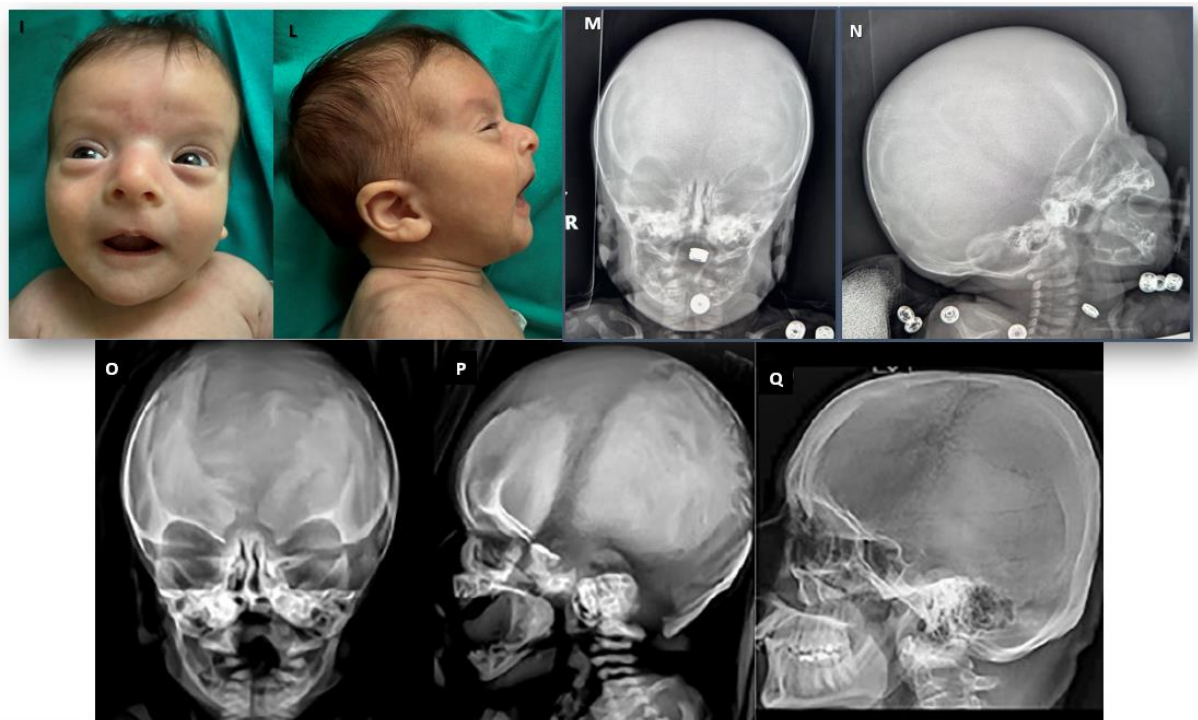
(i-q) Facial phenotype of patient 2 (sister of patient 1) at age 4 months (i,l). Note large forehead, hypertelorism and thin nose Panel shows the skull radiographs of patient 2 (m,n) and patient 1 (o,p) at birth, with very incomplete ossification of the frontal, parietal, and occipital bones leaving large sagittal and coronal sutures (lambdoid suture not well visible). In the lateral skull radiograph of the father (patient 3) (panel q), the fontanelles are close but the frontal sinuses have failed to develop.
